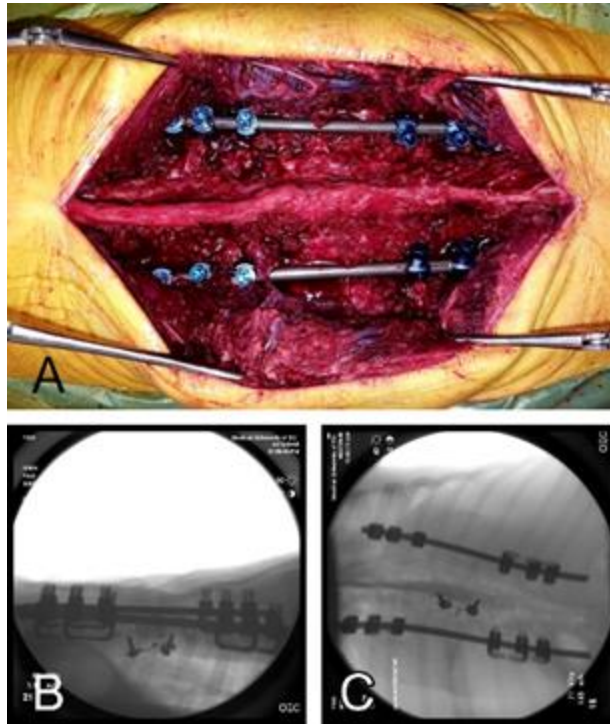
A) Proximal fixation with rib construct T6-T8, hyperkyphosis apex T9-T11, distal fixation with rib construct T12-T14. B-C) post-op radiographs.
